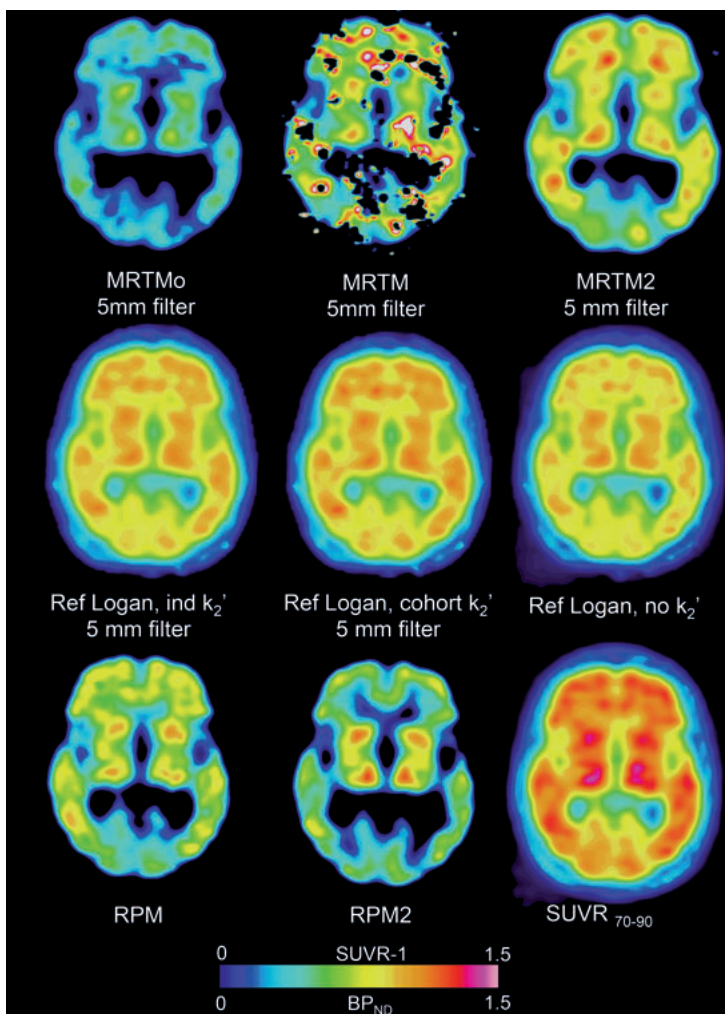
Examples of parametric images from a pAD subject using methods studied in Paper I. Images are either pre-filtered or without applied pre-filter based on which of the two correlated best with 2-TC quantification as indicated in the figure. Top row: multilinear reference tissue model images (from left to right): MRTMo, MRTM and MRTM2. Middle row: reference Logan images (from left to right): with correction for k_2' using individually estimated values, using cohort mean of k_2' and without correction for k_2' . Bottom row (from left to right): RPM, RPM2 and SUVR over 70-90 min.
